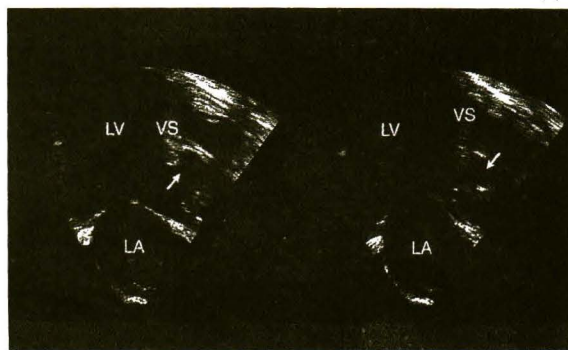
Transesophageal echocardiography of abscess cavity (arrow) expanding from the infected aortic valve to the ventricular septum (vs).
